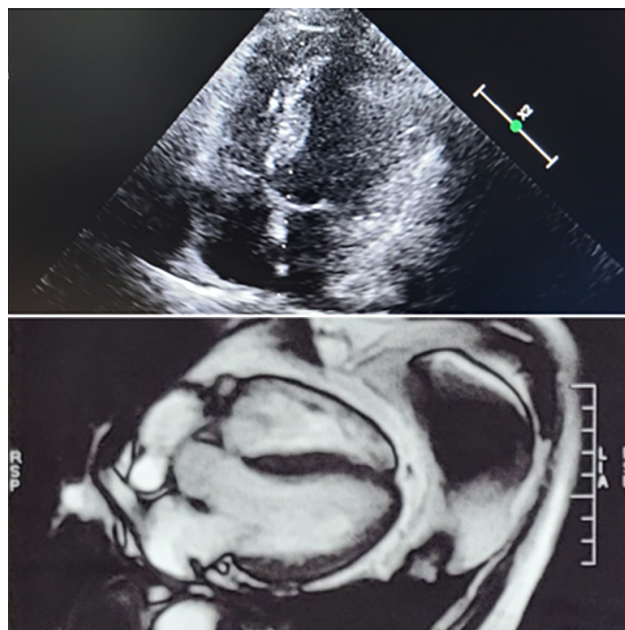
TTE and cardiac MRI images showed no sign of tumour after six cycles of chemotherapy.
